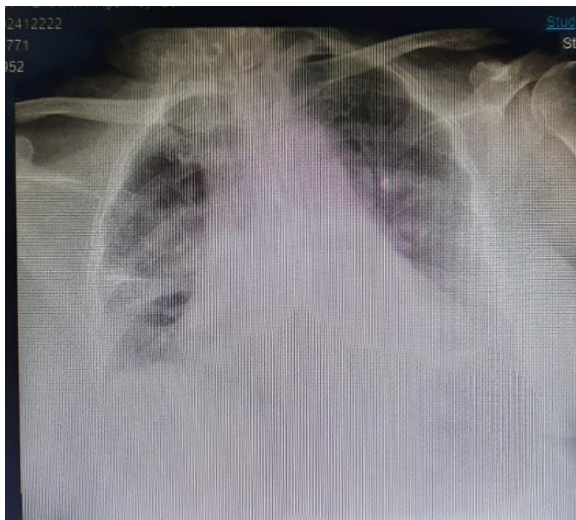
First chest x-ray with pneumonia. (2b) Thorax X-ray evaluation after administration of Linezolid showed improvement
